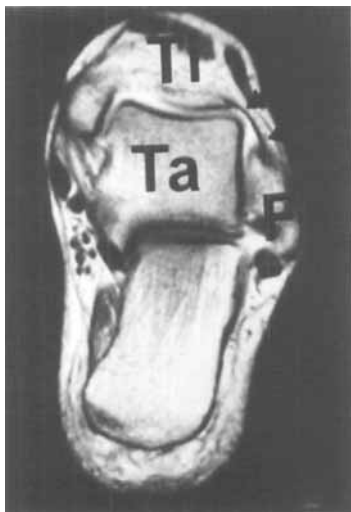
A T1-weighted paracoronal magnetic resonance arthrography image of a right ankle demonstrating the distal fascicle of the AITFL (arrowheads). Ta Talus, Ti Tibia, F Fibula.
